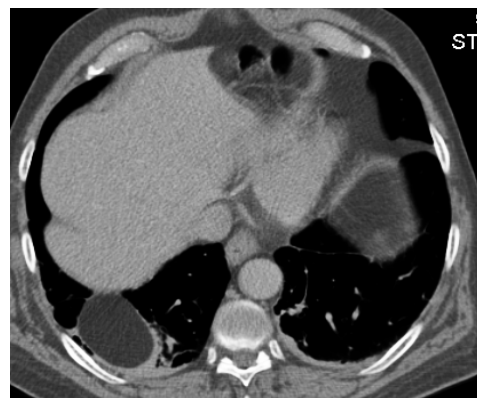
Axial CT, mediastinal window at the level of diaphragm shows a well defined lesion at right lung base with attenuation values consistent with fat proved to be Bochdalek hernia.
